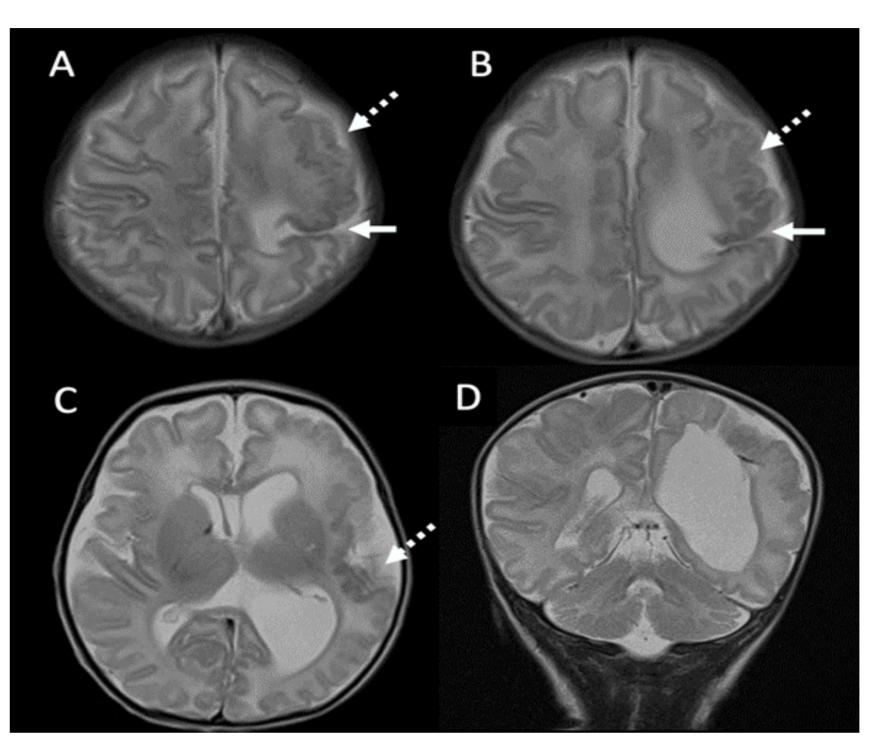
Patient with MT-TH gene mutation. MRI was obtained at the age of 11 days. There is open lip schizencephaly (solid arrows) and extensive polymicrogyria (dashed arrows) in the left cerebral hemisphere. Asymmetrical dilatation of the left lateral ventricle and loss of deep white matter in the left cerebral hemisphere.
